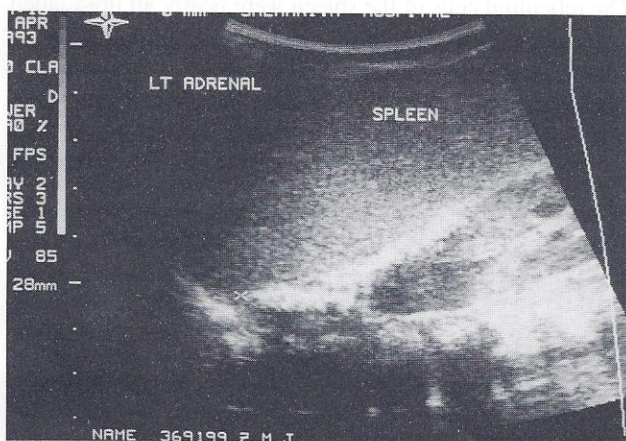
Ultrasound longitudinal through the spleen showing (a) splenomegally (b) echogenic mass with a length of 2.8 cm with slight posterior shadowing in the left suprarenal area
